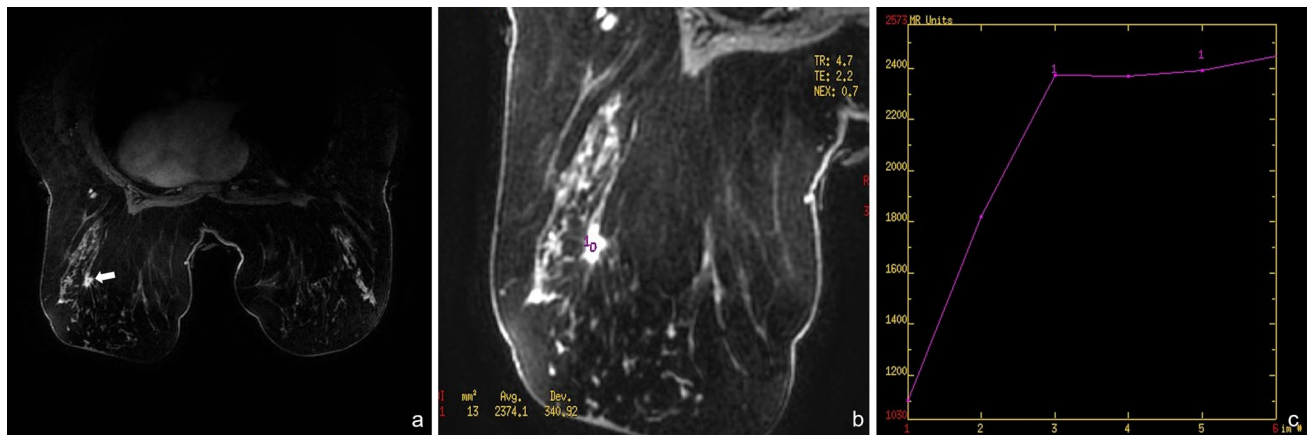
43-year-old woman. Finding a left-sided parenchymal distortion on a screening examination, without hand-hold ultrasound alterations. a DCE image shows a starry lesion in the upper outer quadrant
